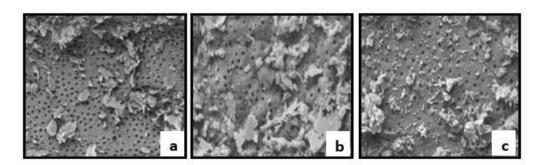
Group C – Conventional multistep irrigation supplemented with ultrasonic agitation; a) Coronal third; b) Middle third; c) Apical third
